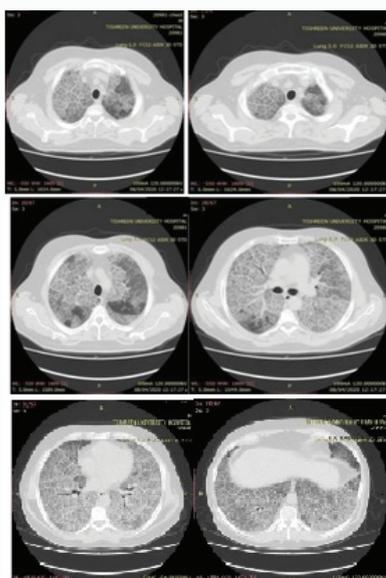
CT of the chest demonstrates bilateral interlobular and intralobular septal thickening with diffuse ground glass opacities which is widely known as “Crazy Paving Pattern”.
